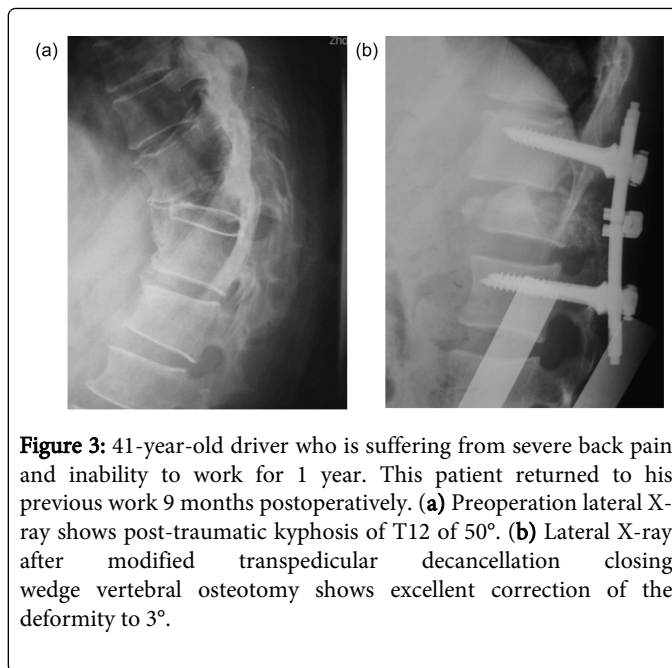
41-year-old driver who is suffering from severe back pain and inability to work for 1 year. This patient returned to his previous work 9 months postoperatively. (a) Preoperation lateral X-ray shows post-traumatic kyphosis of T12 of 50° . (b) Lateral X-ray after modified transpedicular decancellation closing wedge vertebral osteotomy shows excellent correction of the deformity to 3° .
